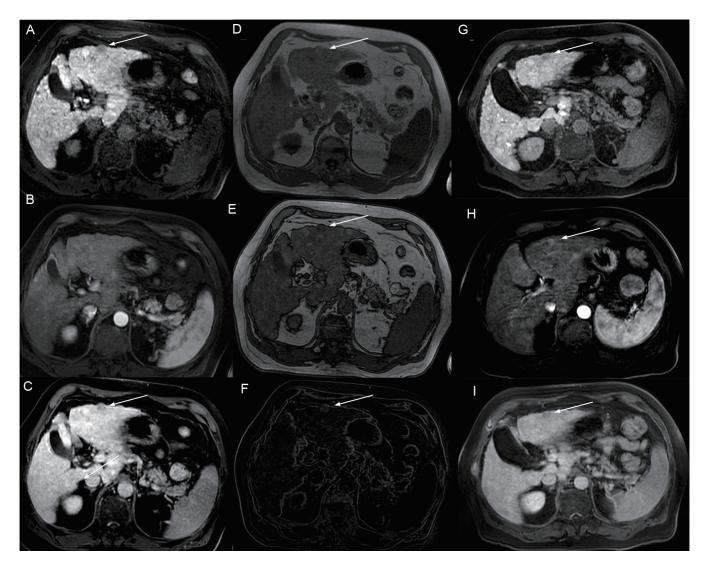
Axial MR images demonstrating a 14 mm hypointense nodule in the hepatobiliary phase (HBP) located in the liver segment 3. (A–C) It (arrow in A) does not show hypervascularization in the arterial phase (B) but exhibits a washout appearance in the portal venous phase (arrow in C). (D–F) In-phase T1-weighted images documented the presence of slightly hyperintense components (arrow in D) but the more evident loss of signal intensity in the out-of-phase T1-weighted images (arrow in E), confirming the intratumoral fatty metamorphosis; the digital subtraction of the out-of-phase from in-phase T1-weighted images made the chemical shift artifacts even more evident and the nodule appeared strongly hyperintense on a dark background (arrow in F). (G–I) Follow-up axial MR images of the same nodule performed after 1 year confirmed the dimensional stability of the lesion in HBP (arrow in G) but revealed the appearance of arterial phase hyperenhancement (arrow in H); together with the persistence of washout in the portal venous phase (I), arterial hypervascularization confirmed the malignant evolution to overt hepatocellular carcinoma (HCC).
